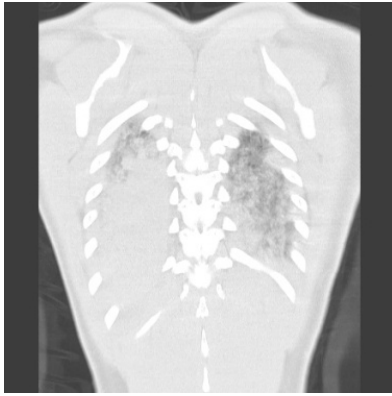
On coronal CT examination there was pneumonic consolidation and infiltration dominantly in lower lobe
